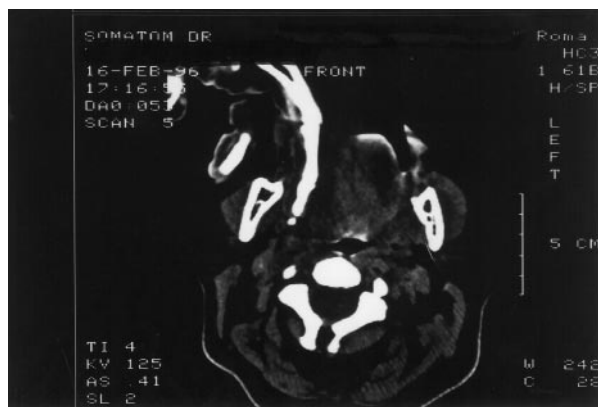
Intraoral palpation: CT imaging.
